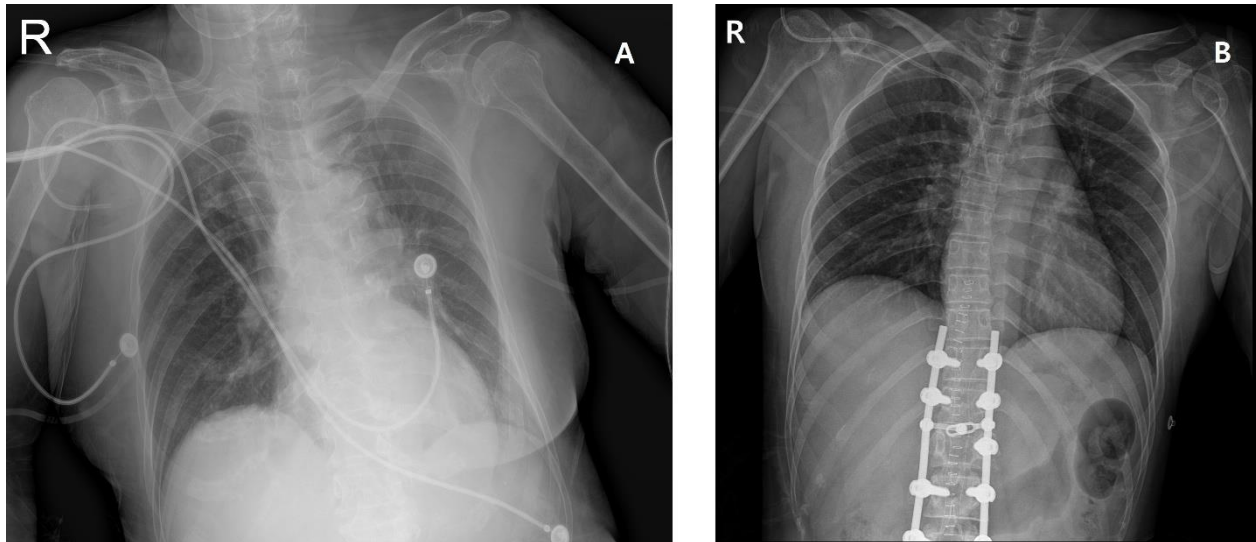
post-procedural chest radiography
